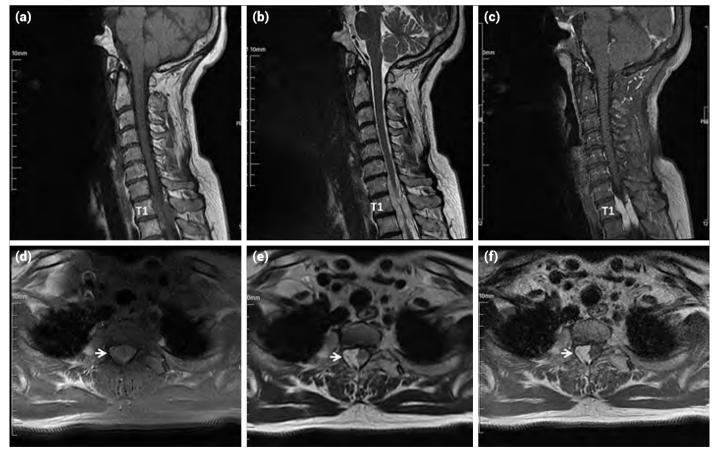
Magnetic resonance images of the thoracic epidural lesion. An isointense lesion is seen throughout the T1-T2 levels on sagittal (a) and axial (d) T1-weighted images (white arrow). The same lesion appears slightly hyperintense on sagittal (b) and axial (e) T2-weighted images (white arrow). The lesion occupies the right half of the spinal canal and compresses the spinal cord. The lesion exhibits an intense and homogeneous enhancement on the post-contrast sagittal (c) and axial (d) T1-weighted images (white arrow).
